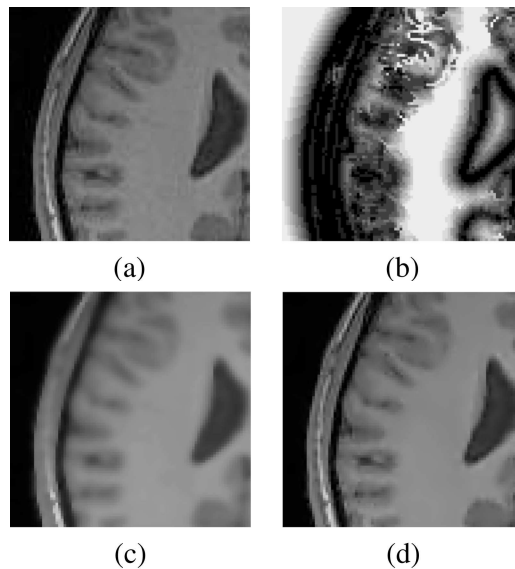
(a) Region of MRI image of human head. (b) Scale image that corresponds to (a). (c) The same region in (a) after anisotropic diffusion filtering. (d) The same region in (a) after adaptive B-spline smoothing.
